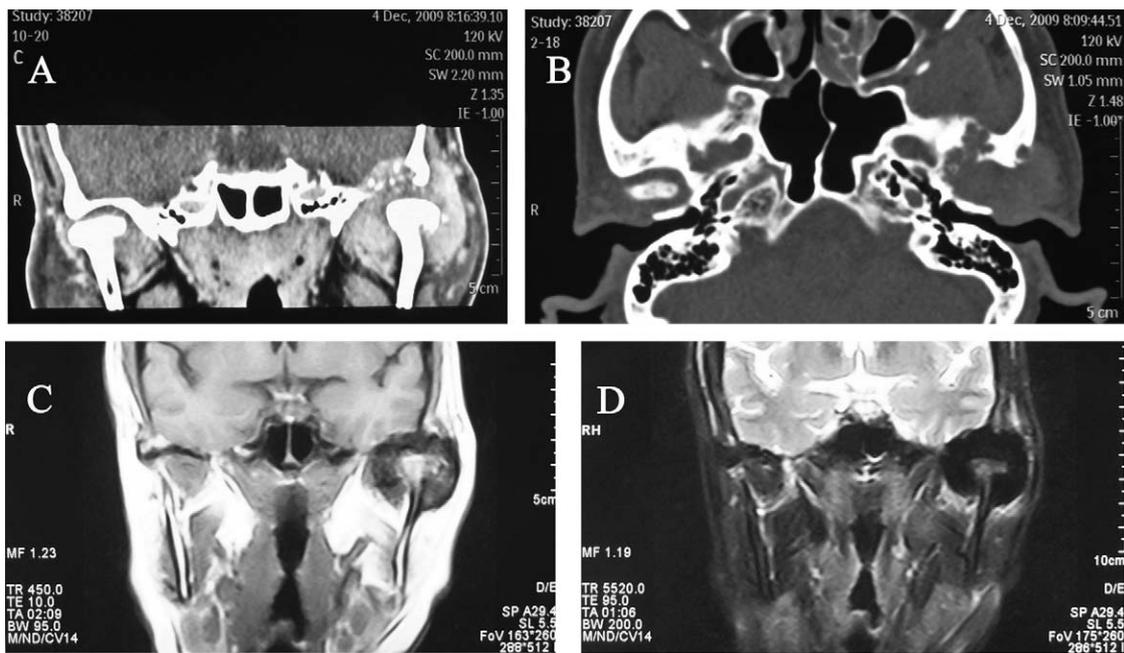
Preoperative CT: soft-tissue window coronal section (A) and bone window axial section (B). Preoperative coronal MRI: T1-weighted SE sequences (C) and T2-weighted TSE sequences (D).
